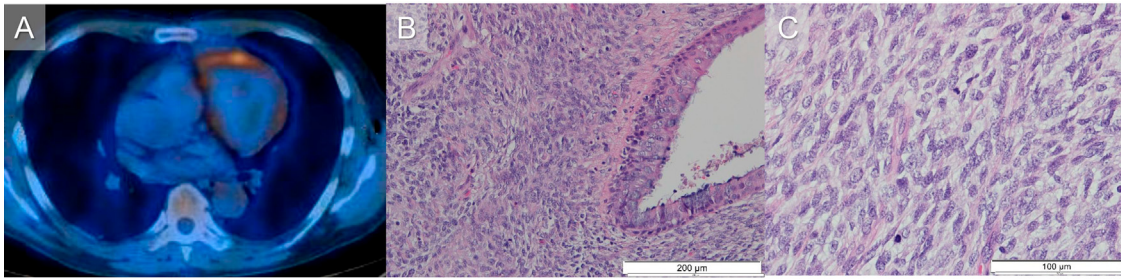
(A) PET scan image showing high accumulation of FDG in the pulmonary mass. (B) Spindle cell tumor with infiltration of bronchial structures (HE 200X). Magnification bar = 200 μ m. (C) Atypical neoplastic cells with frequent mitotic figures (HE 400x). Magnification bar = 100 μ m.
